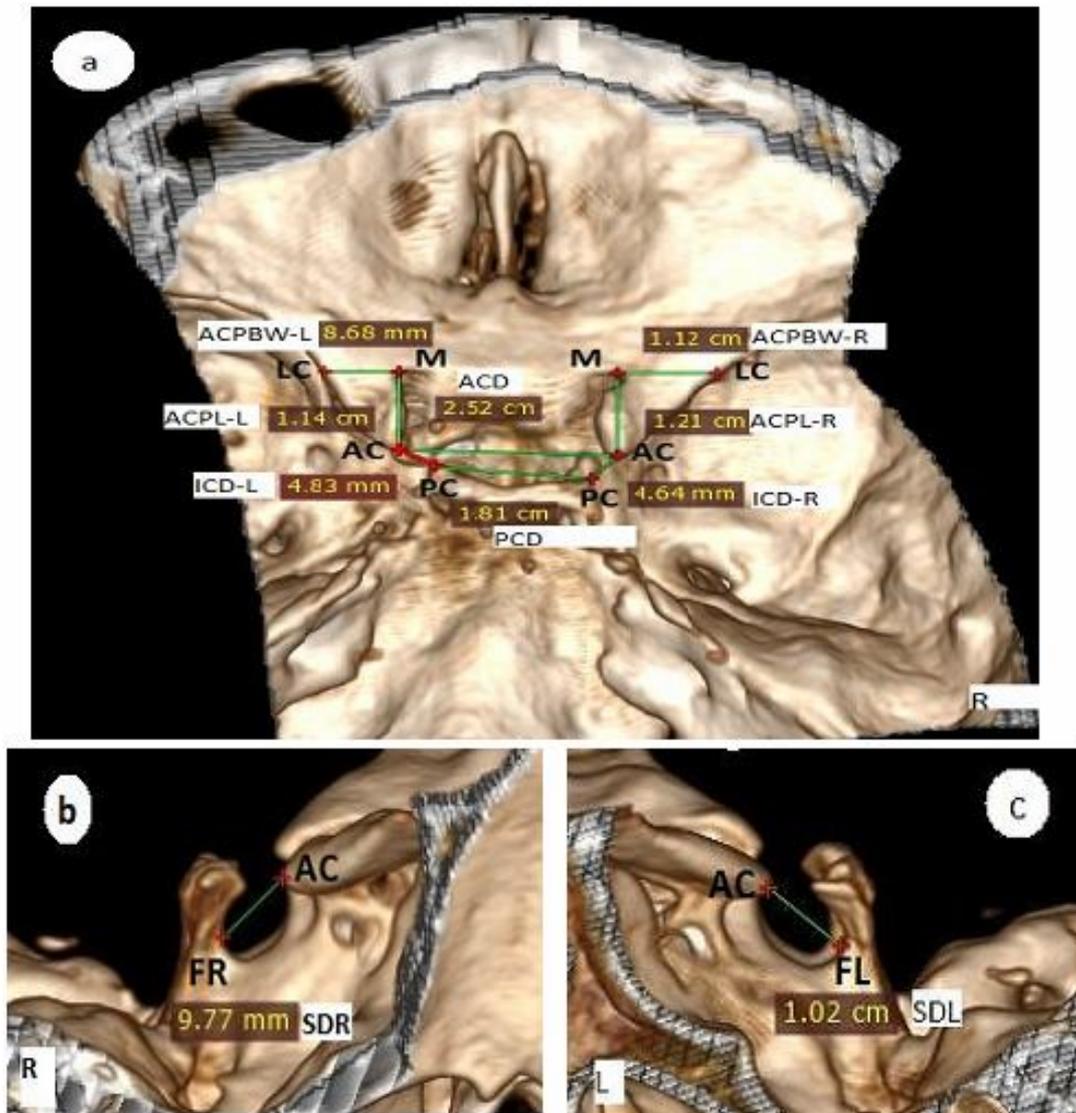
Three-dimension reconstruction CT images of a female skull: (a) axial view of Sella Turcica from top of the head showing : ACD: anterior clinoid distance, the distance between the apices of the anterior clinoid processes (AC) on both sides, PCD : posterior clinoid distance, the distance between the apices of the posterior clinoid processes (PC) on both sides, ICD-R: interclinoid distance right side, the distance between AC and PC on right side, ICD-L: interclinoid distance left side, the distance between AC and PC on left side; ACPBW-R Anterior clinoid process basal width right side: the distance between the medial margin of the optic canal (M) and the lateral edge of anterior clinoid process (LC) on right side; ACPBW-L Anterior clinoid process basal width right side the distance between M and LC on the left side. ACPL-R: anterior clinoid process length right side, measured as the distance between AC and M on the right side; ACPL-L: anterior clinoid process length left side measured as the distance between AC and M on the left side. (b) The right-side view of the Sella Turcica showing SDR Sella diameter right, the distance between the furthest point on the right border (FR) of Sella Turcica and AC on the same side (c) the left side view of Sella Turcica showing SDL Sella diameter left the distance between furthest point on the left border of Sella Turcica (FL) and AC on the same side. R: right side, L: left side.
